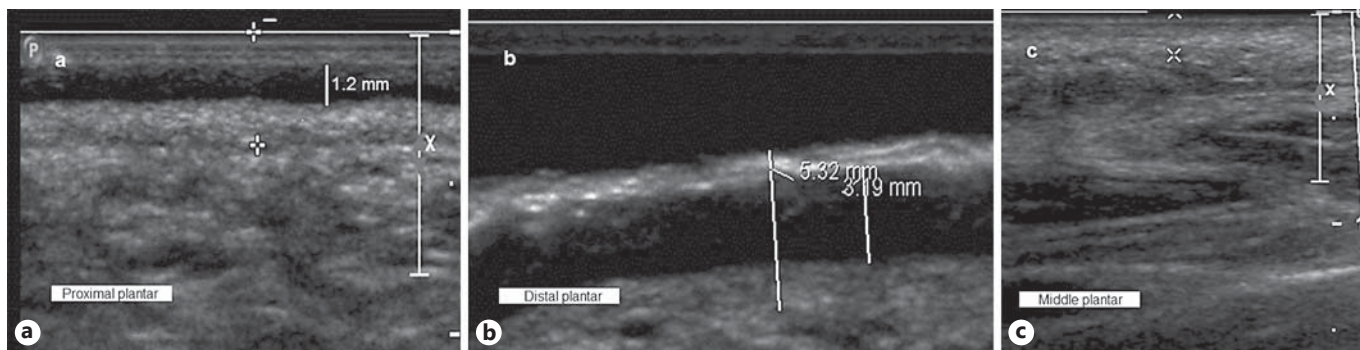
Ultrasound scans over the plantar skin foot at different levels in a PC patient. The width of the anechoic layer interposed between the epidermis and the dermis varies from 1.2 mm at the proximal plantar area (a) to 3.2 mm at the distal plantar area
